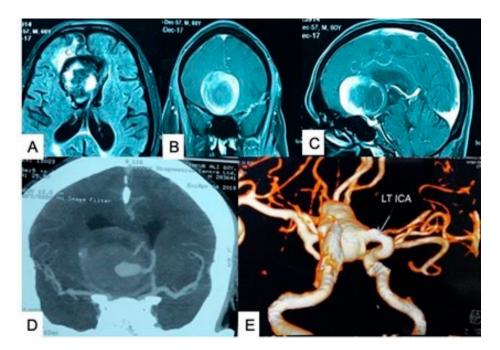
(A–C) MRI axial, coronal and sagital view showing a thrombosed ACOM aneurysm. (D) CT angiogram in coronal view showing a partially thrombosed ACOM aneurysm. (E) CT angiogram showing a giant ACOM aneurysm. Source: Figure by authors.
